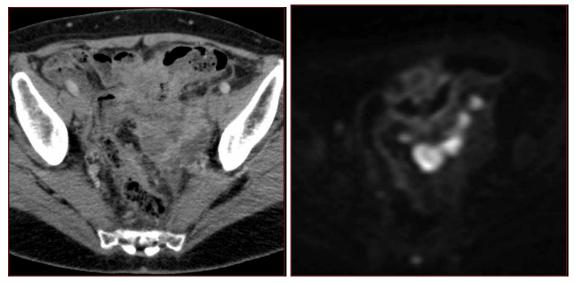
MSCT tumor of the sigmoid colon. T2-weighted images show a welldefined lesion in the perisigmoid space. DWI was obtained at b = 750 and shows a high signal.
